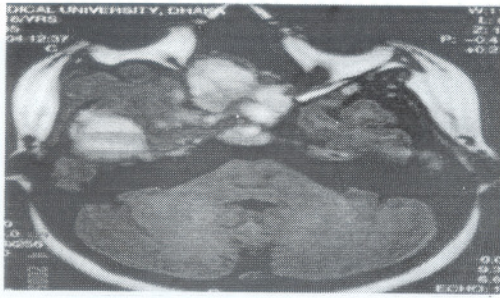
Noncontrast axial T1 W MR image of brain shows- mixed intensity mass lesion having fluid fluid levels.
